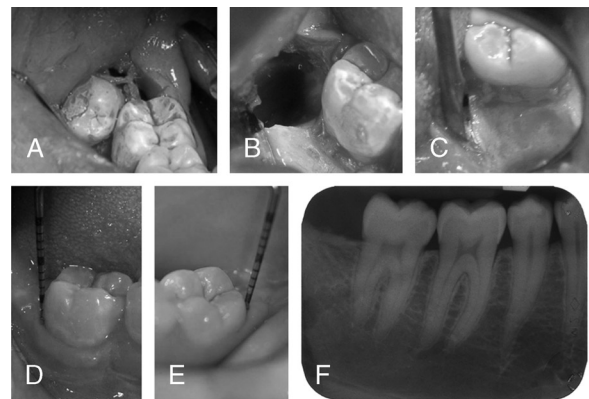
The impacted tooth was surgically exposed (A) and carefully extracted (B). A well-defined bone cortical margin at the distal aspect of tooth 47 is visible (C). Three years after third-molar extraction, physiological probing depth values are measured on both the buccal (D) and lingual (E) aspects of the tooth 47. The periapical radiographic image confirms the complete reformation of bone and the elimination of any periodontal defect at the distal aspect of tooth 47 (F).
